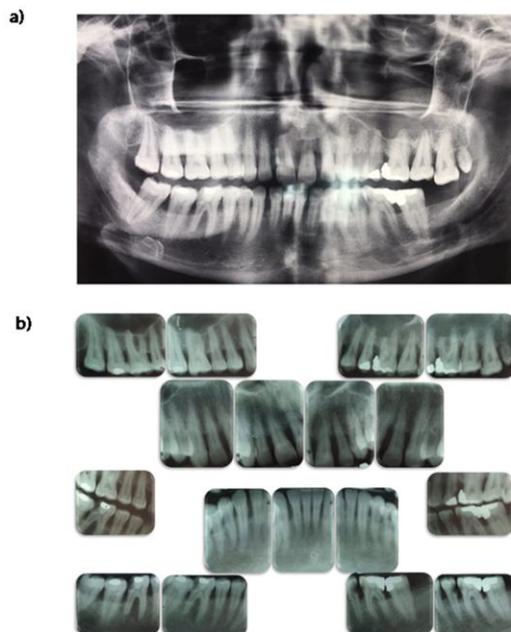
a: patient's OPG ,b: Patient's full mouth radiographs.
